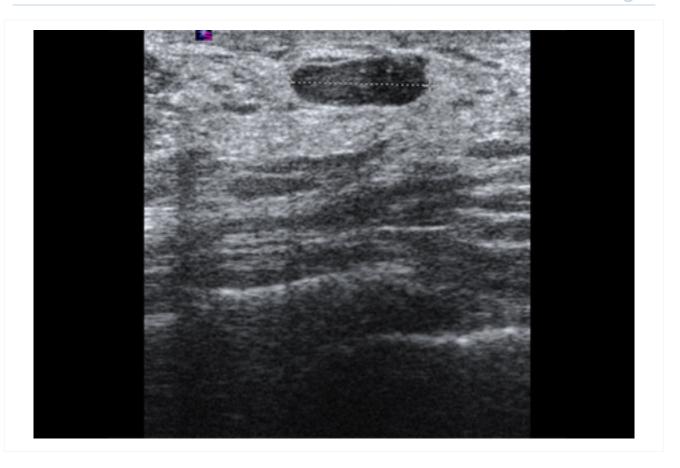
Ultrasonographic image of a fibroadenoma
